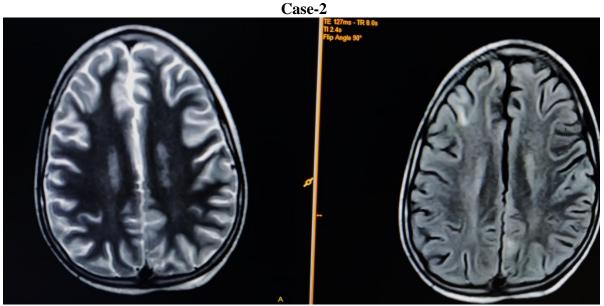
Axial T2-WI and FLAIR images showing focal gyral FLAIR hyperintensity noted in right frontal region- superior frontal sulcus pattern- Atypical PRES
